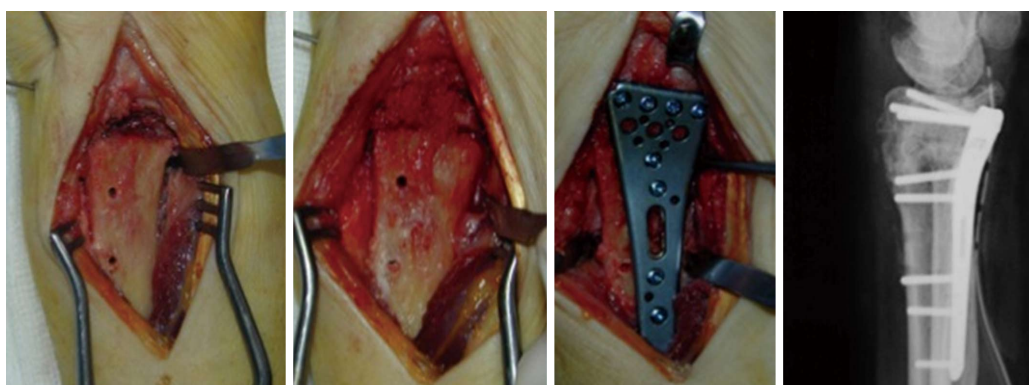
Intraoperative view and post-operative X-rays of the surgical procedure using a volar locking plate and cancellous bone graft.
